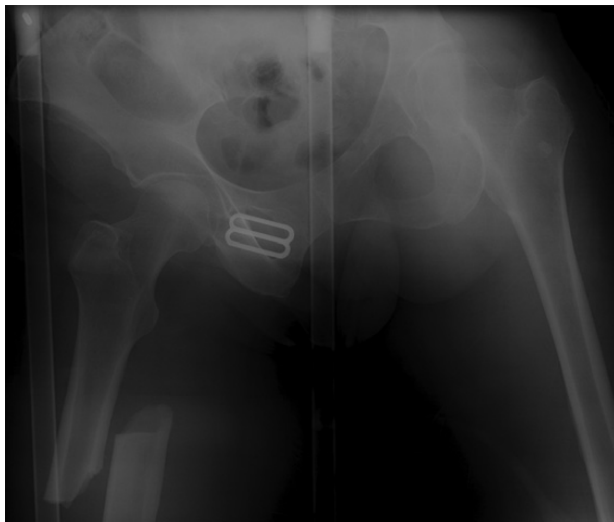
Anteroposterior radiograph of the pelvis of a patient on chronic bisphosphonate therapy, who sustained a fall. Note the hallmarks of atypical femur fractures: subtrochanteric location, transverse fracture line, lateral cortical thickening, and a medial cortical spike.
